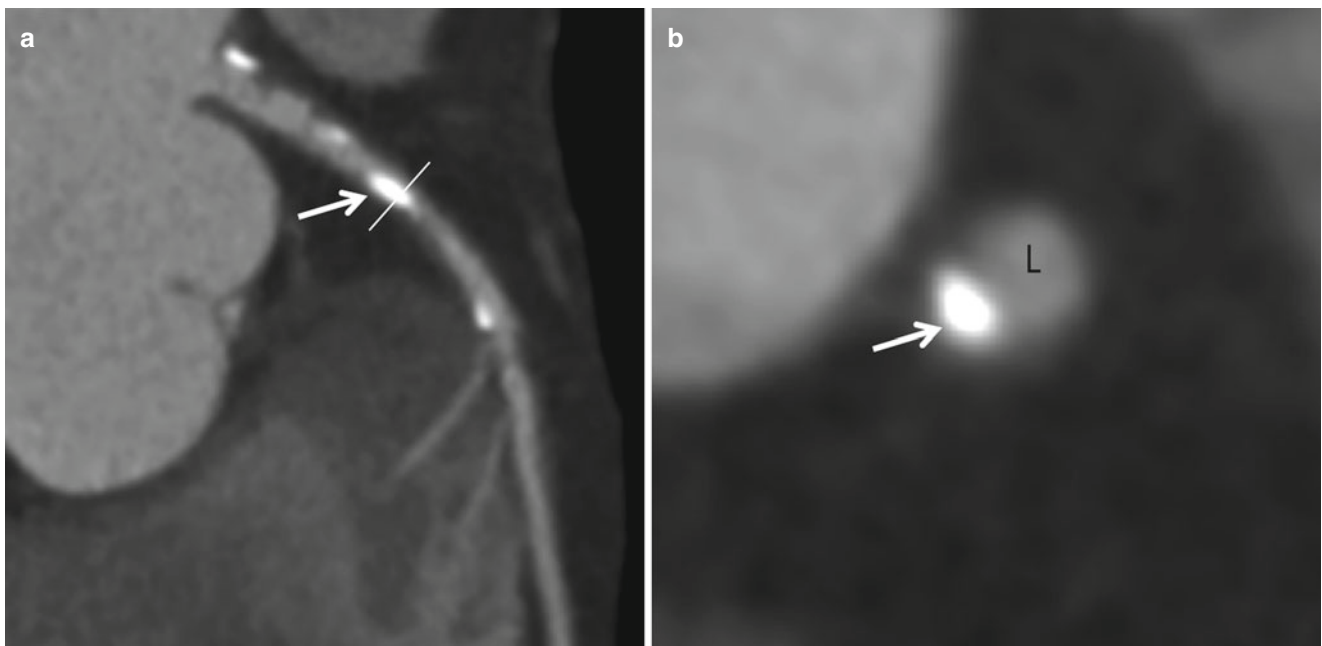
Calcified plaque. (a) Curved multiplanar reformatted (MPR) image of coronary computed tomographic angiography (CCTA) demonstrates multiple calcified plaques in the left main and proximal segment of left anterior descending artery (*arrow*). (b). Cross-sectional
